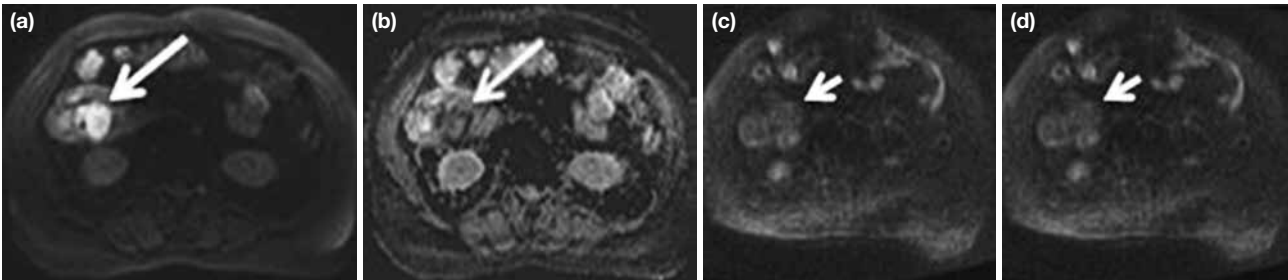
a–d. A 72-year-old woman presenting with right-sided abdominal pain and leukocytosis (white blood cell count, 16.600/ μ L [reference value, <10.000/ μ L]). Initial diffusionweighted MR image and ADC map show pericecal abscess formation (long arrow) due to perforated appendicitis (Plastron appendicitis) that has markedly high signal intensity on diffusion image with corresponding low signal intensity on ADC map (a, b). On control diffusion-weighted MR images after medical treatment the abscess has disappeared (short arrow) (c, d).
